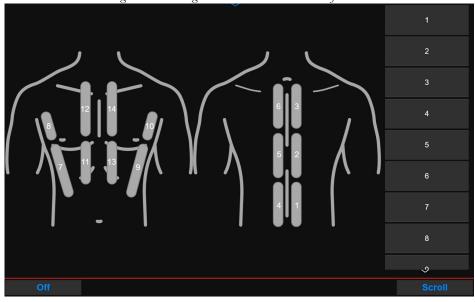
Lung Ultrasound Thorax Projections
